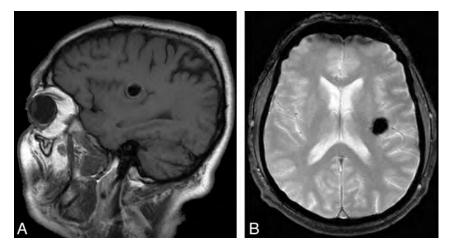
Sagittal TI and gradient-echo MR imaging of a 64-year-old man with a left insular cavernoma in whom left insular epilepsy (definite) developed. Round, hypointense TI, T2, and T2* lesion involves the anterior and posterior long gyri of the insula.
